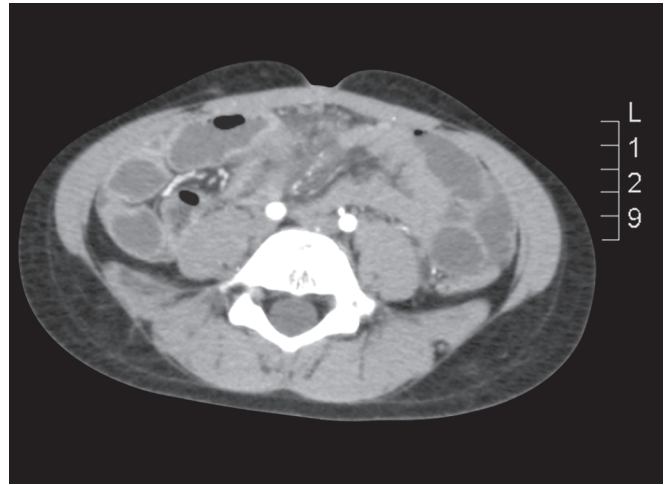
Computed tomography scan showing irregular thick wall fluid collection with inflamed mesenteric fat plan (complicated urachal cyst vs Meckel's diverticulum)
